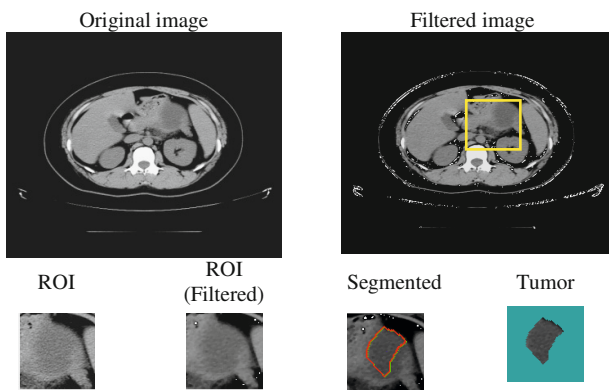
The ROI of CT images with contrast injection
